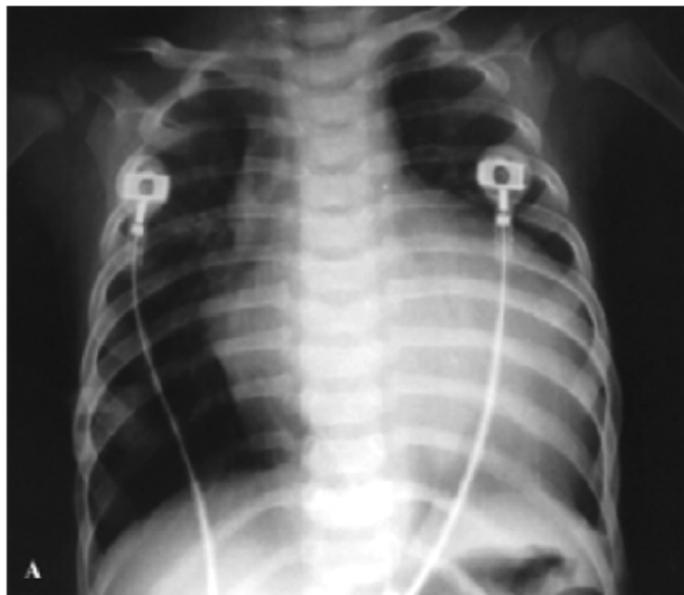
Chest X-ray of the patient which revealed cardiomegaly and oligoemic lung fields.
